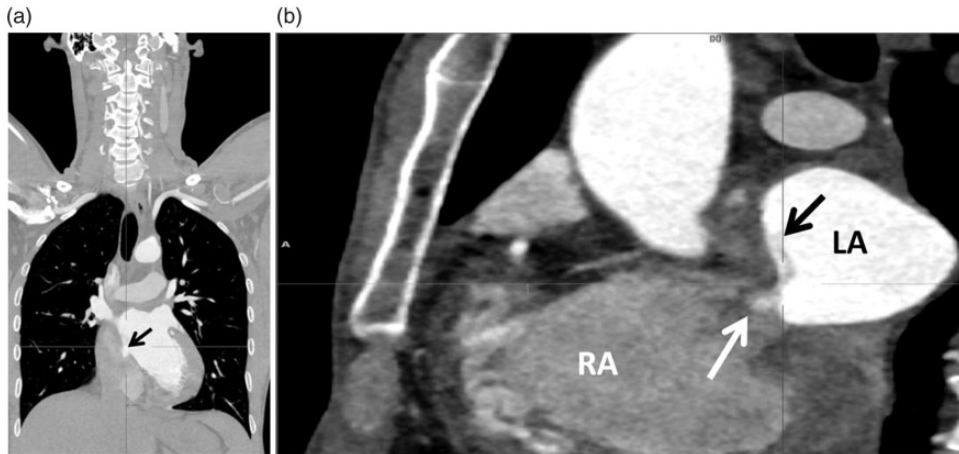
Cardiovascular computed tomography angiogram findings in a patient with patent foramen ovale (black arrow) (a). A close-up image of A shows a distinct left atrial flap in the expected location of the septum primum (LA, black arrow) and a definite jet of contrast material into the unopacified right atrium (RA, white arrow) (b).
